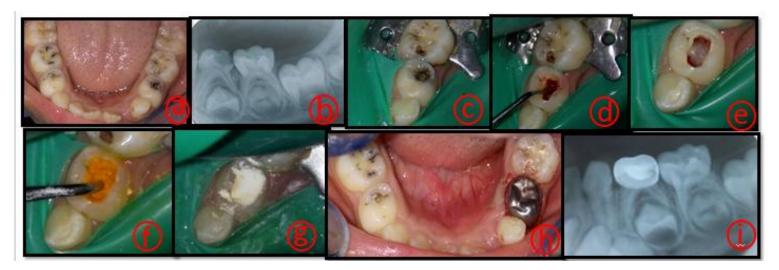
Antioxidant-mix: a - Preoperative photograph. b-Preoperative radiograph. c- Rubber dam isolation. d-Access cavity. e- Stasis of amputated pulp. f- Placement of Antioxidant- mix. g- Reinforced ZOE dressing. h-Postoperative photograph. i- Postoperative radiograph.
